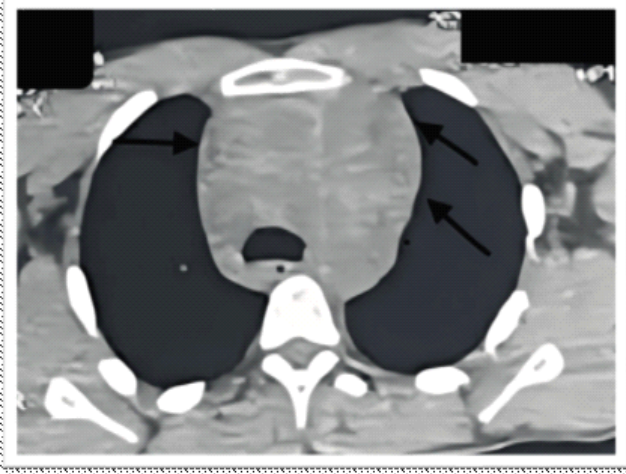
Axial chest CT image showing a retrosternal mediastinal hematoma adjacent to the aortic arch.
